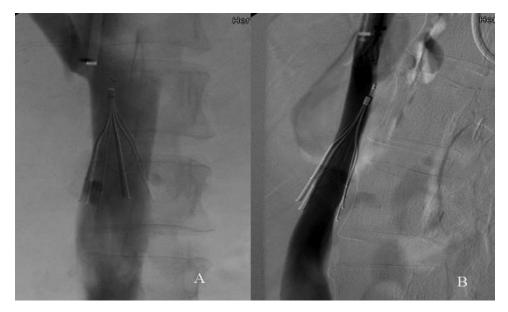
This figure shows a filter that was not retrieved due to inability to snare the retrieval hook. Although, in an AP projection, there is no tilting (A), a lateral cavogram reveals posterior tilting with embedding of the hook into the posterior wall of the cava (B). Valsalva maneuvers did not correct the radiographic abnormality.
